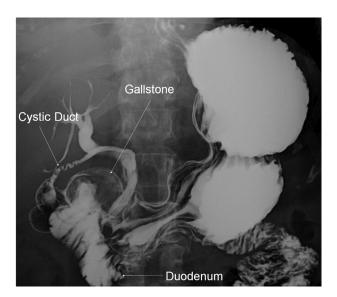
A radiograph of the abdomen acquired following the fluoroscopic study reveals that the gallstone remains impacted within the duodenum. The cystic duct and duodenum remain opacified.
